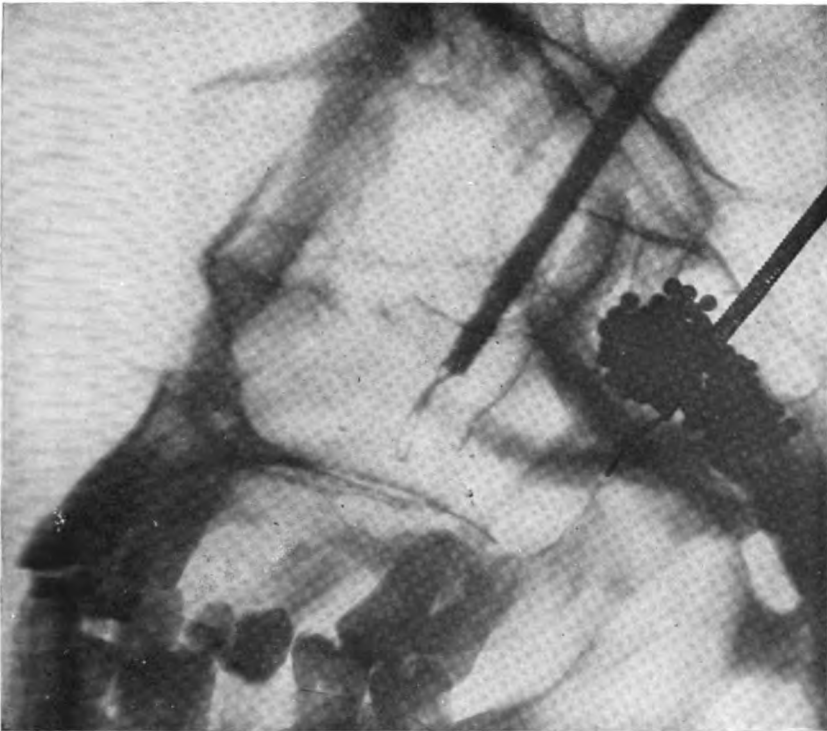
Lateral radiograph of the sphenoid cells full of lead in an empty skull.
